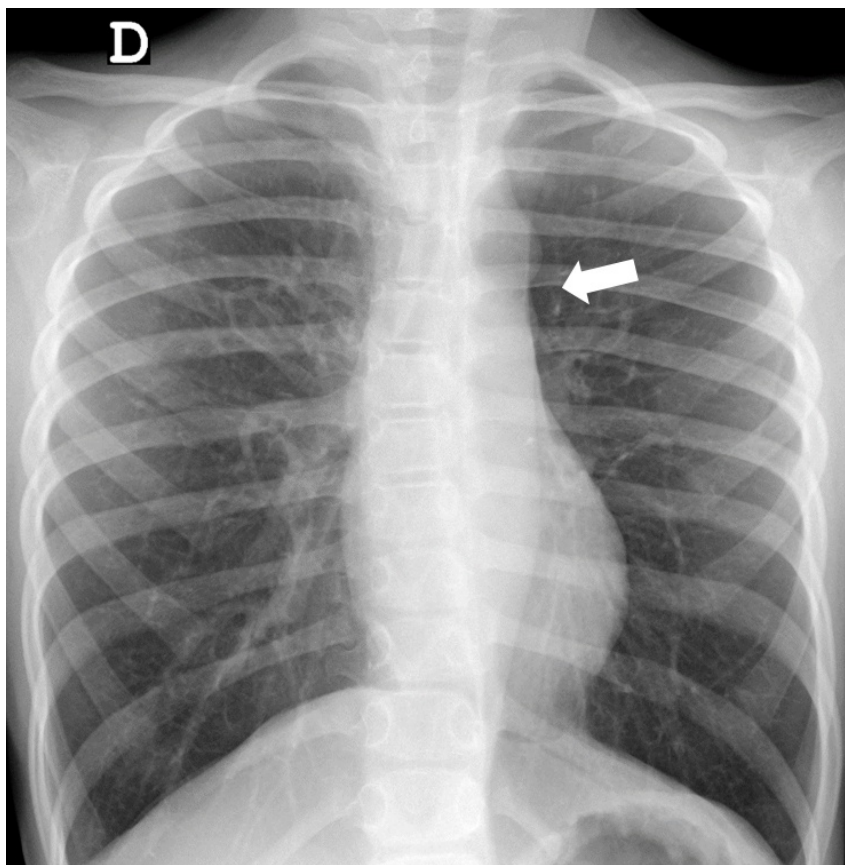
Plain chest radiograph. The figure 3 sign is formed by prestenotic dilatation of the aortic arch and left subclavian artery, indentation at the coarctation site and post-stenotic dilatation of the descending aorta.
